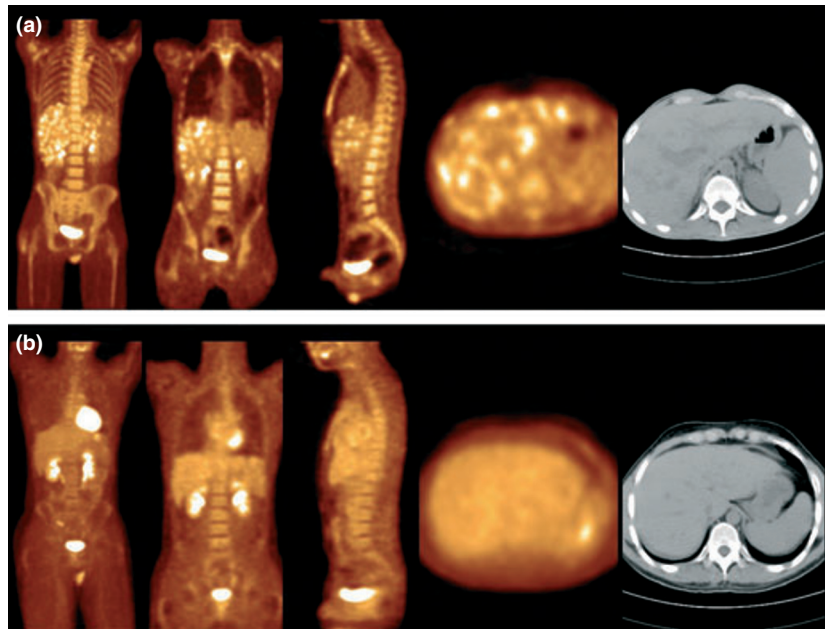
(a) Accumulation of [^{18}F]2-fluoro-2-deoxy-D-glucose ([^{18}F]FDG) in the liver before antifungal treatment in a patient with hepatosplenic candidiasis. (b) Three months after the beginning of antifungal therapy, [^{18}F]FDG uptake has disappeared.
